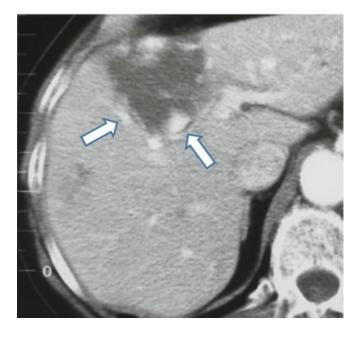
Incidental detection of a low density liver lesion with nodular peripheral contrast enhancement (*arrows*) on early phase contrast-enhanced CT. The finding is highly suggestive of hemangioma, which can be confirmed by progressive centripetal contrast fill-in on a later phase imaging
